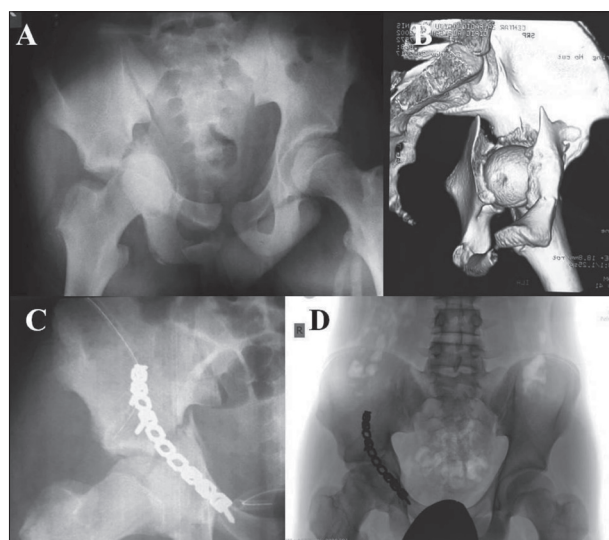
T-fracture of the acetabulum in a 14-year-old patient; in such fractures, surgical reduction and fracture fixation is usually performed with a combined anterior and posterior Kocher–Langenbeck approach in one act or staging surgery at intervals of two to three days; given the patient's age and fracture reduction achieved, we used only anterior approach and further treatment was continued with cutaneous traction for three weeks; A: X-ray after the injury; B: 3D computed tomography view after the injury; C: X-ray after fracture fixation through the anterior ilio-inguinal approach; D: X-ray after six months
